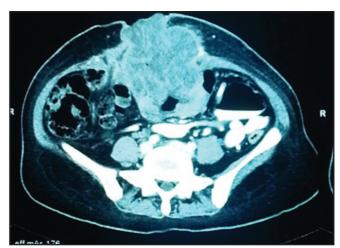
Computed Tomography scan of the sub-umbilical region showed a large mass in the upper-central abdomen. The mass protruded through the anterior abdominal wall at approximately the level of the umbilicus.
